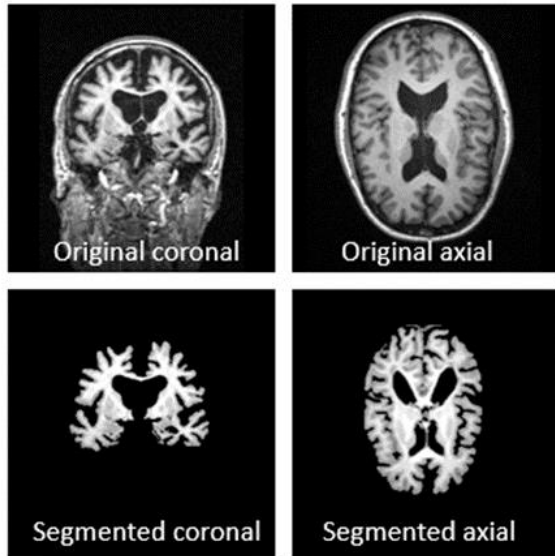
MRI slices in coronal and axial planes in original form and after processing with segmentation algorithm.
